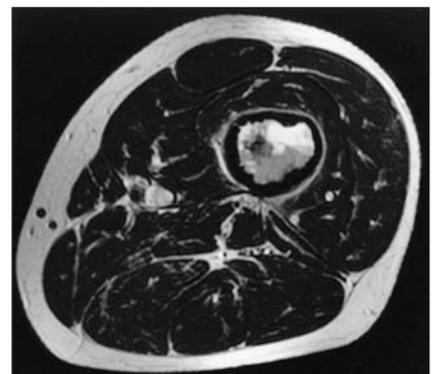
MRI: transverse axial  $T_2$ -weighted image.
